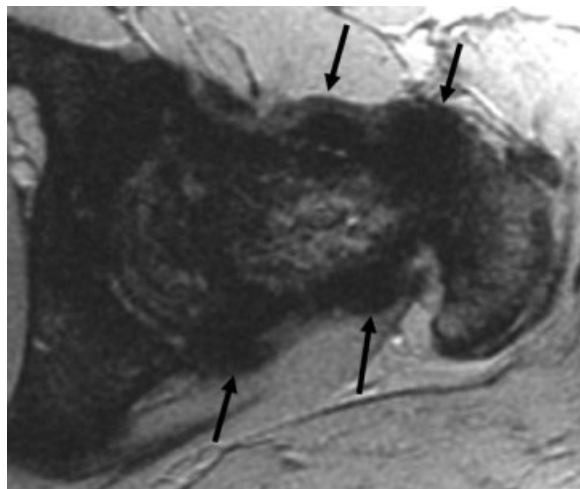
Axial gradient echo MR image in a patient with the diffuse form of pigmented villonodular synovitis (arrows) demonstrates the characteristic low signal intensity synovial deposits due to the paramagnetic effect of hemoglobin degradation products.
